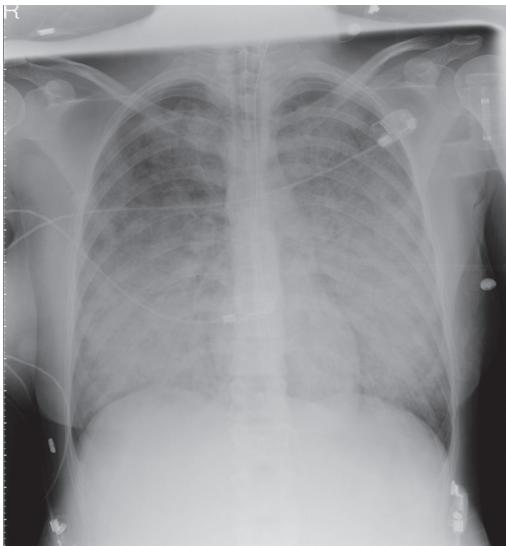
Bilateral infiltrates on chest X-ray in a patient with TRALI
